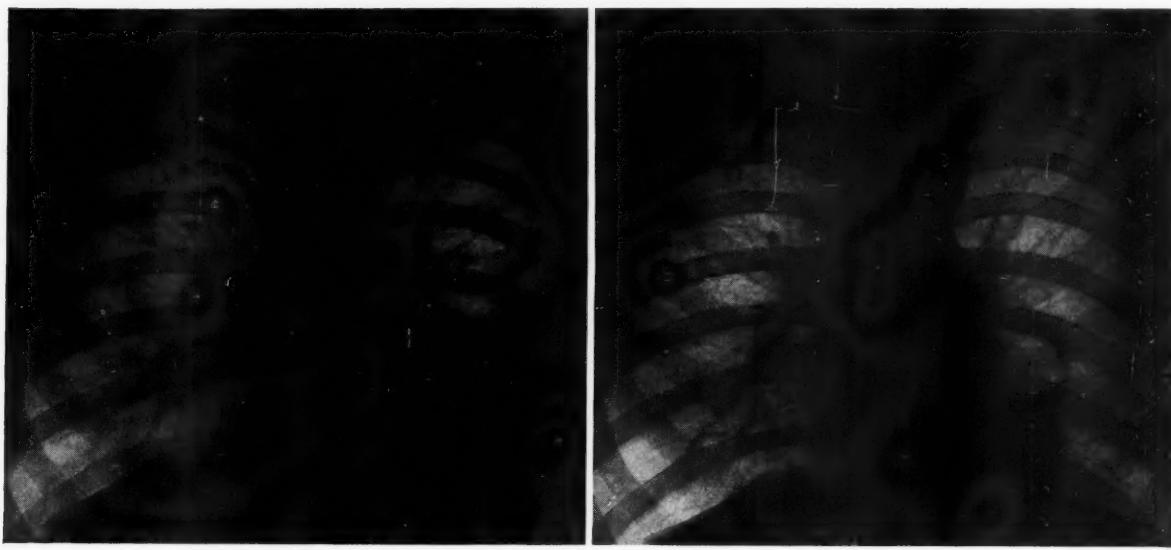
Case III. A, chest roentgenogram before treatment; patchy consolidation is present in the left lower lobe. B, seven and one-half weeks after beginning 2-hydroxystilbamidine; only thickened pleura persists.
